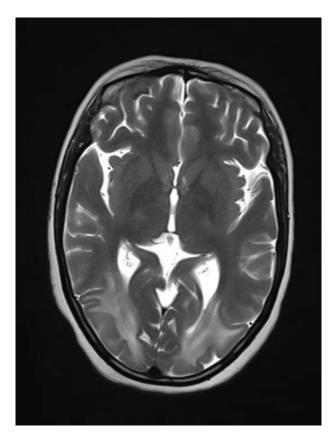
MRI Brain Axial T2 weighted image showing hyperintensity in bilateral; occipital lobes.
